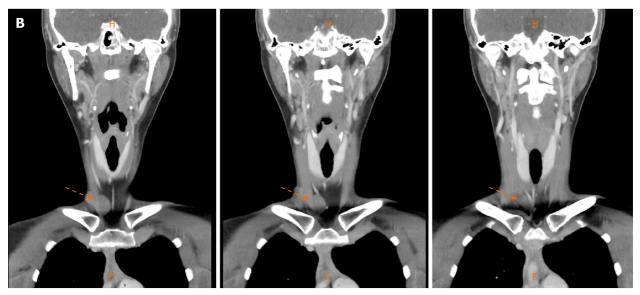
Enhanced computed tomography of the neck. A: Non-enhancing round mass on the subcutaneous area in the anterior neck area in axial view; B: Serial images of coronal section.
